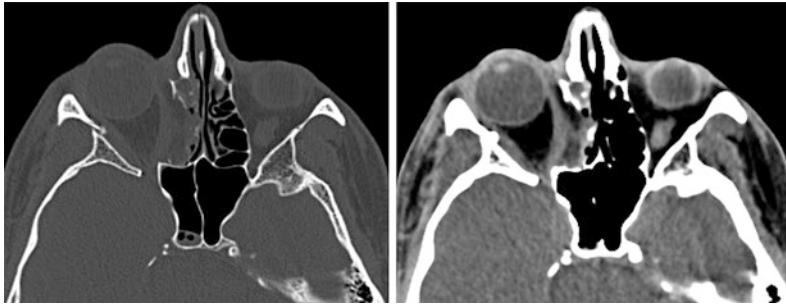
Fracture of the medial orbital wall. Axial CT image demonstrate fracture of the medial orbital wall (lamina papyracea) with loss of its normal medial bulge. Associated entrapment of the medial rectus muscle is noted
